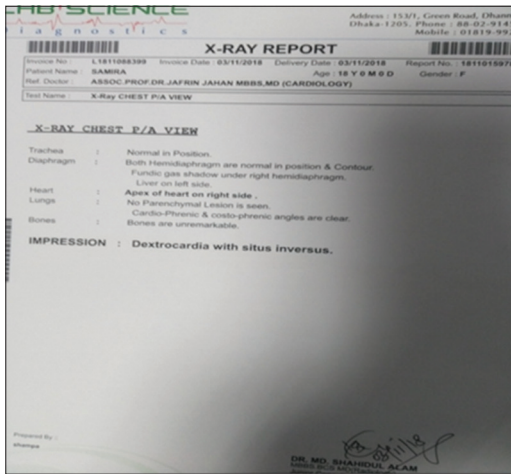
Chest X-ray report
